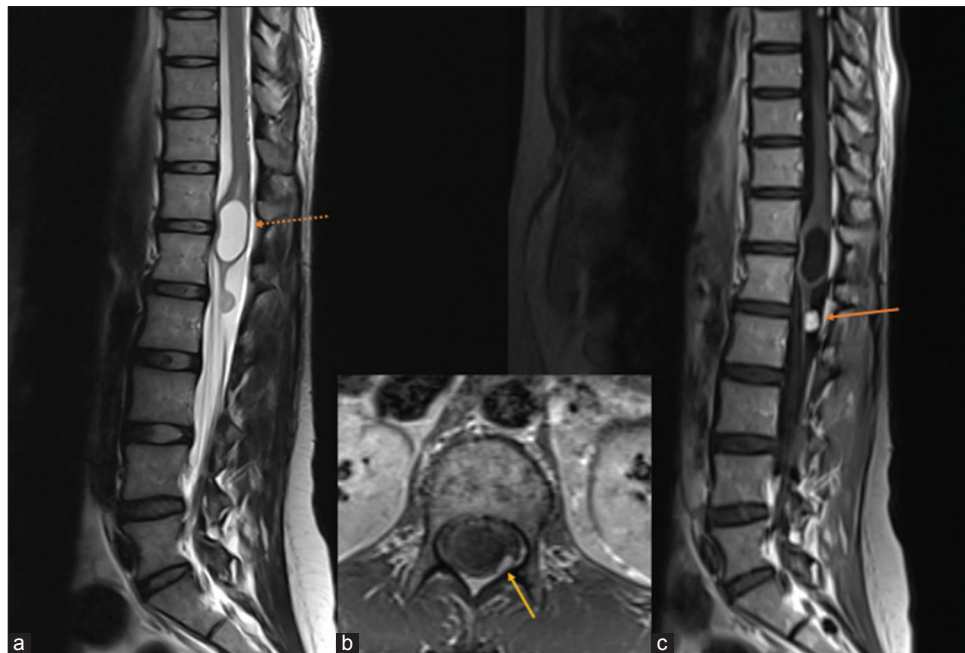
(a) The orange dotted arrow exhibits a cystic conus medullaris tumor on a sagittal T2 magnetic resonance imaging (MRI) between T12 and L1 with an underlying nodular lesion. (b) Axial T1 gadolinium MRI between T12 and L1 shows a small posterior left mural nodule around the cystic cavity, advocating for a possible spinal hemangioblastoma (yellow arrow). (c) Sagittal T1 gadolinium MRI shows a homogeneous contrast enhancement of the cauda equina tumor (orange arrow) between L1 and L2.
